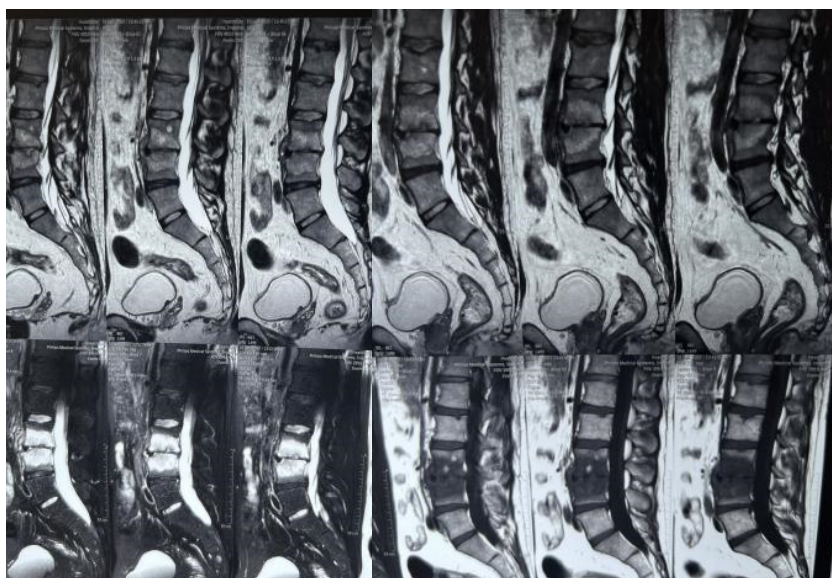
MRI of the spine patient No. 1, 01.2022. (before the first course of treatment). Picture of spondylodiscitis L3-L4 in the subacute phase, L3 retrolisthesis, ossification, and edema of the anterior longitudinal ligament.
